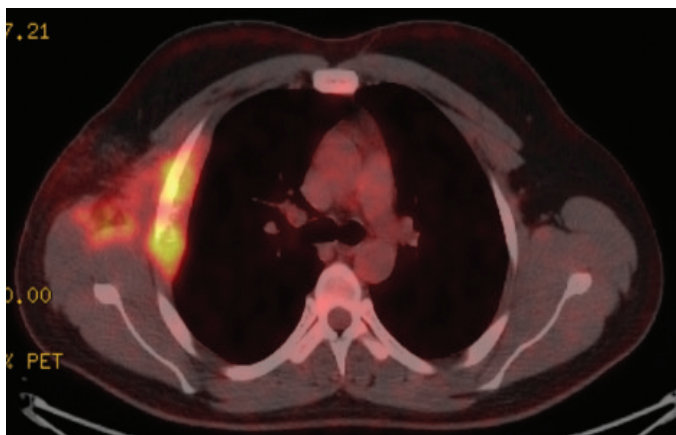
PET-CT, increased activity in lateral of the right 3-4. intercostal area and 3rd rib
